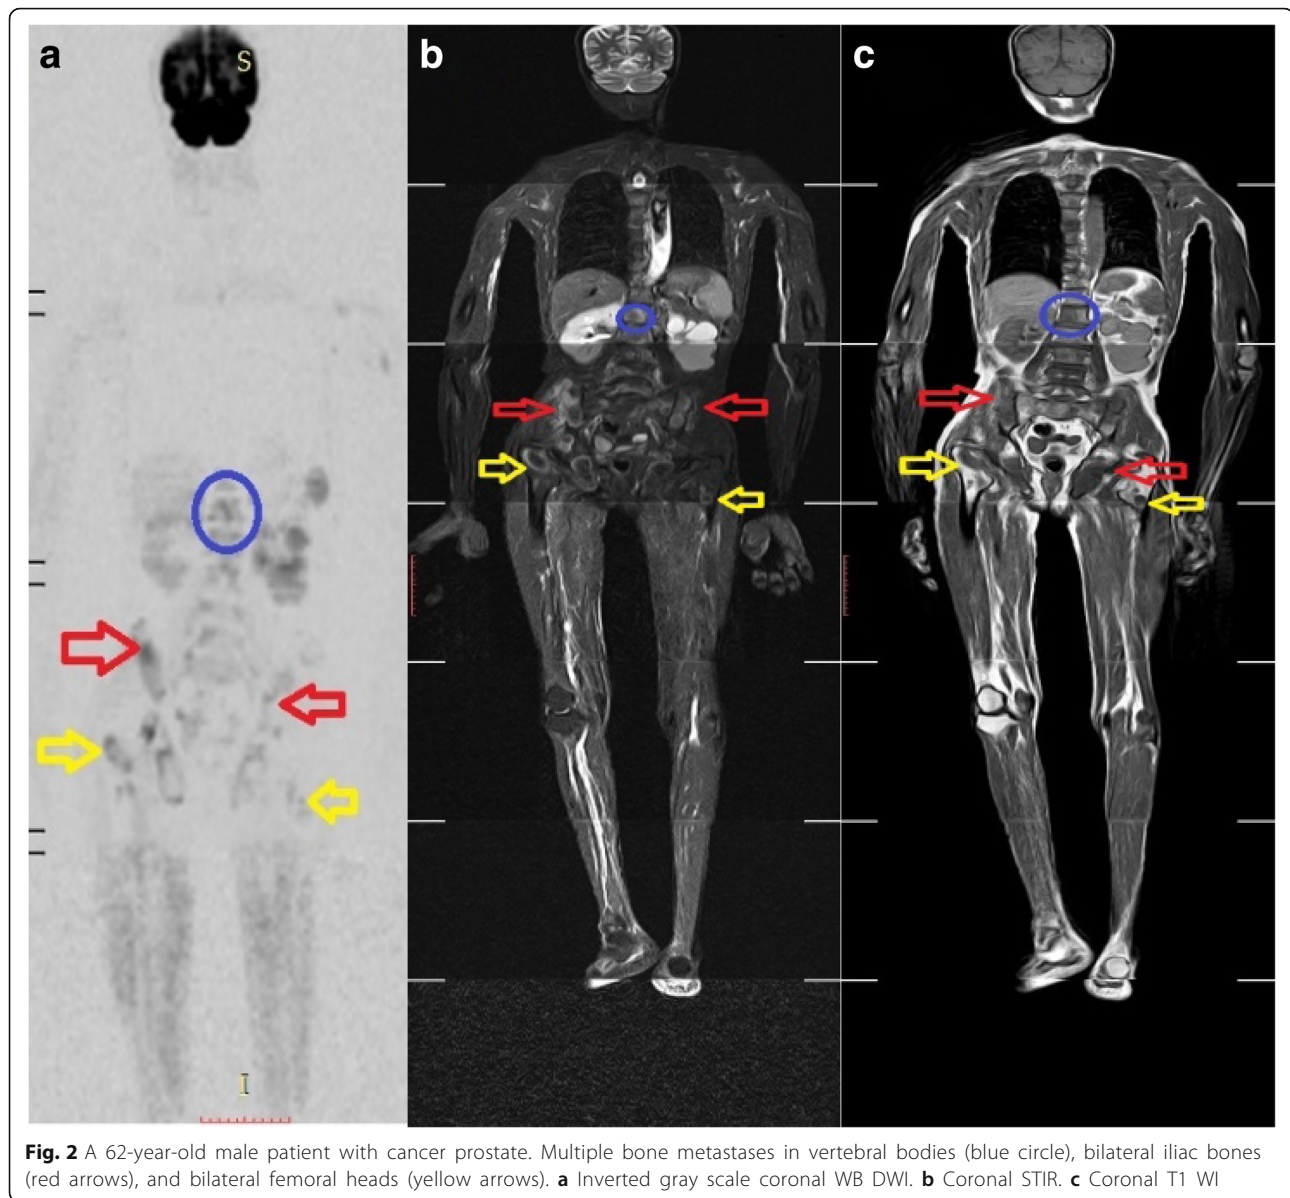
A 62-year-old male patient with cancer prostate. Multiple bone metastases in vertebral bodies (blue circle), bilateral iliac bones (red arrows), and bilateral femoral heads (yellow arrows). a Inverted gray scale coronal WB DWI. b Coronal STIR. c Coronal T1 WI
